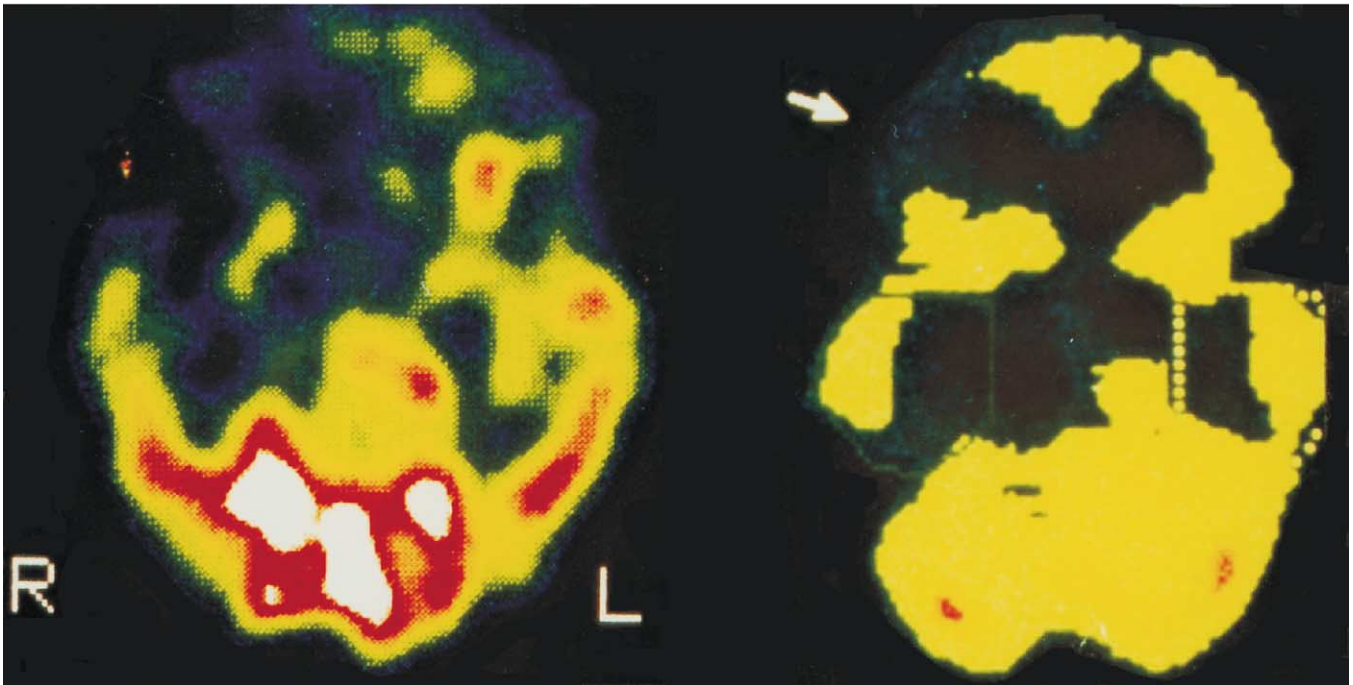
Horizontal SPECT images through the brains of two patients with selective retrograde amnesia for autobiographical information. The section on the left is from a patient with a probable organically based amnesia (herpes simplex encephalitis). It was done 3 years postinfection and demonstrates the area of hypoperfusion in the right temporofrontal region. The section on the right shows the brain of a patient with probable psychogenic amnesia. Again, a significant metabolic reduction is visible in the right temporofrontal junction zone. L, left; R, right (from Plate 2 of Markowitsch, H.J., 1999, *Functional neuroimaging correlates of functional amnesia. Memory* 7, 561–583. Reprinted by permission of Psychology Press Ltd., Hove).
